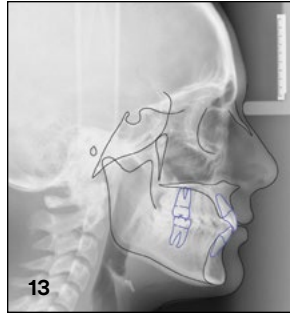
Final cephalometric radiograph and tracing.
